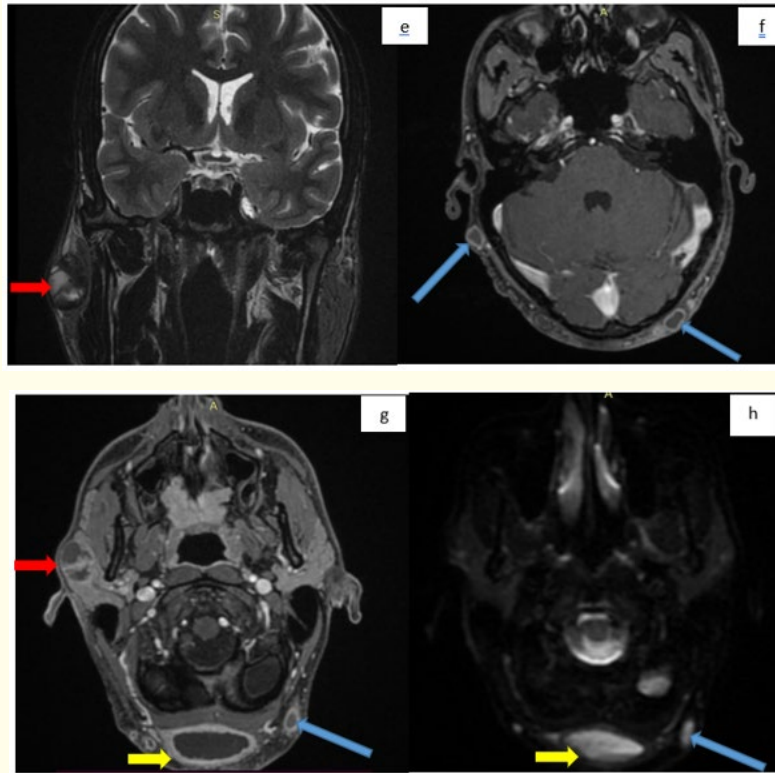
Figure e-h: Cerebro-facial MRI.
